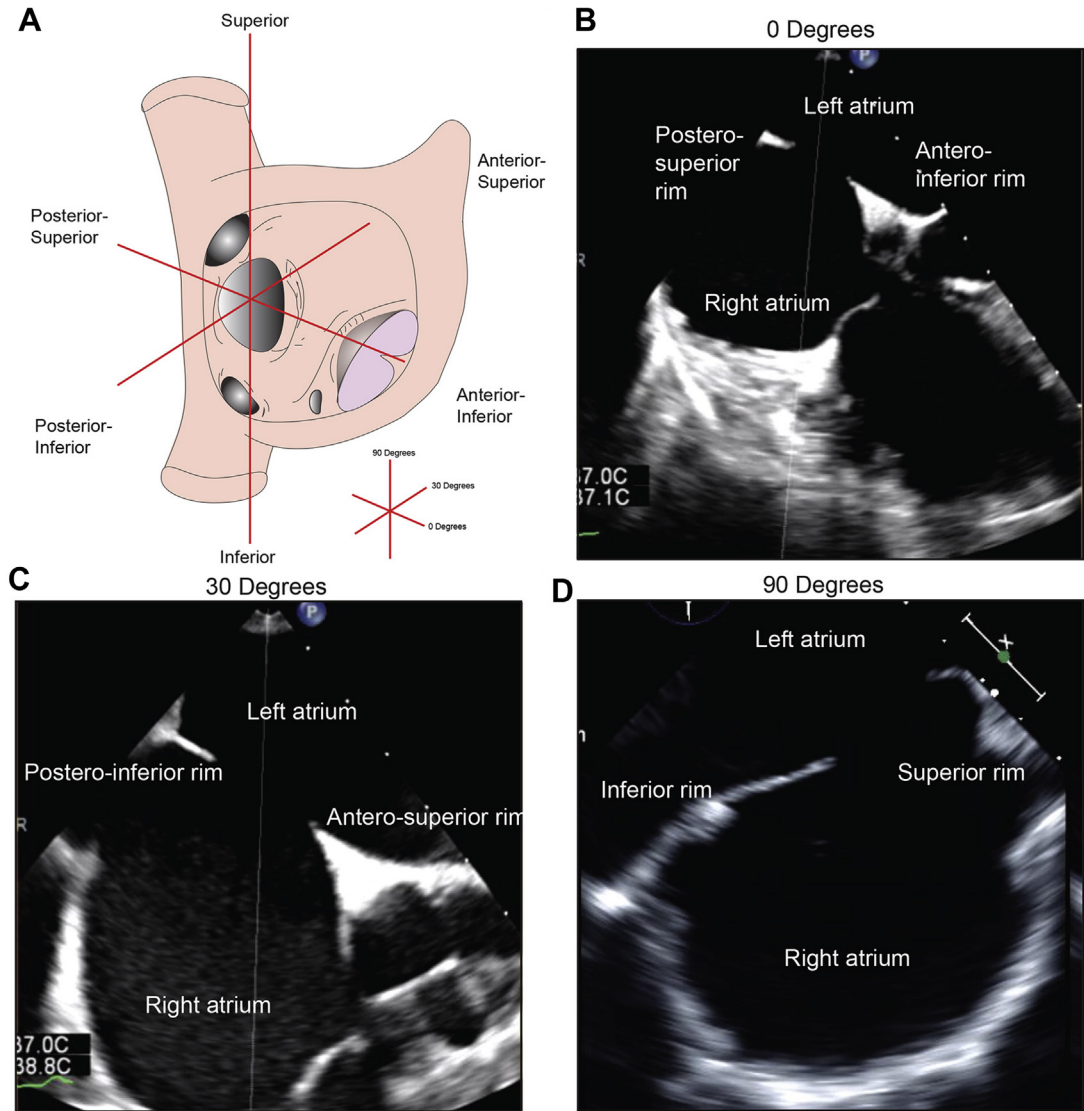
Transesophageal imaging planes of the interatrial septum. Imaging planes of the interatrial septum (A) when evaluated by TEE include mid esophageal views at 0° (B) demonstrating the posterosuperior and anteroinferior rims and at 90° show the superior and inferior rims (D). High esophageal views at 30° (C) are required to demonstrate the posteroinferior and anteroinferior rims.
